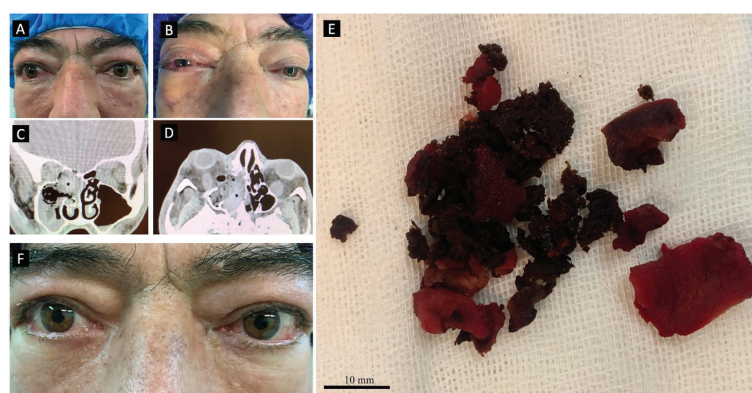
Orbital compartment syndrome in a patient after orbital decompression A 67-year-old patient before (A) thyroid orbital decompression and use of oxidized regenerated cellulose and gelatin sponges due to intraoperative bleeding. Development of orbital compartment syndrome (B) 10h after the procedure with a hyperdense intra-sinus lesion (asterisk) exerting compressive effects on the posterior orbital tissues on coronal (C) and axial (D) orbital CT scan. Patient was re-operated and expanded oxidized regenerated cellulose and gelatin sponges (E) were removed. In 3-week postoperative follow-up (F), the best corrected visual acuity was 20/70 with negative RAPD and 3-mm decreased proptosis. CT: Computed tomography; RAPD: Relative afferent pupillary defect.
